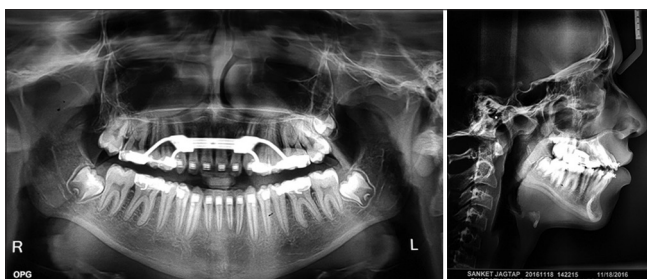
Progress radiographs
